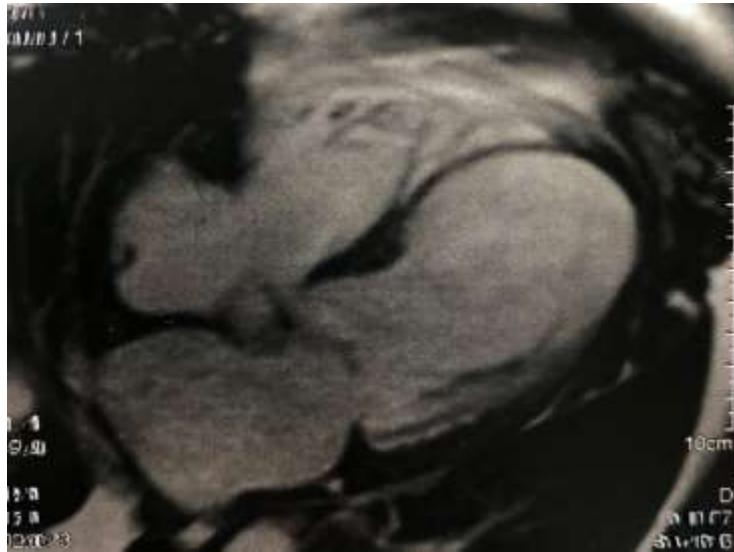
Apical 4 chambers showing wide neck inferoseptal wall
